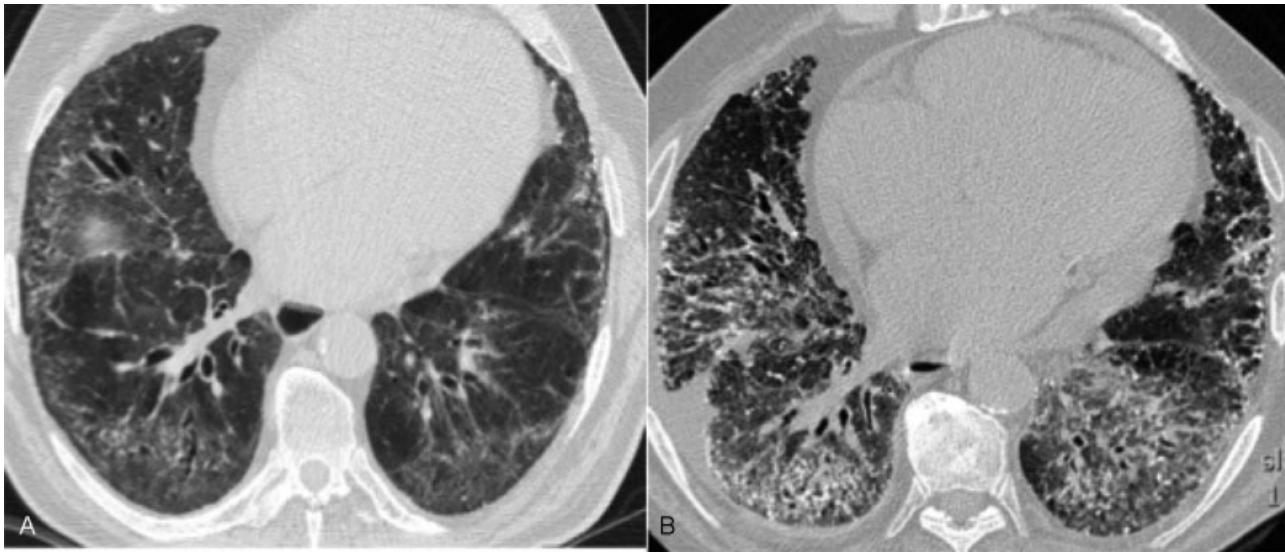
Evolution of a case of fibrotic NSIP related to scleroderma, confirmed by surgical lung biopsy. (A) Baseline HRCT. Mild peripheral reticulation, with traction bronchiectasis and subpleural sparing, is present. (B) Follow-up HRCT, after 4 years. Severe thickening of interlobular septa with associated multiple dendriform calcification in middle lobe, lingula, and both lower lobes. Multiple traction bronchiectasis and a relative subpleural sparing are visible as well. A moderate pericardial effusion associated with pleural bilateral is evident. Significant esophageal dilation is present in both exams.
